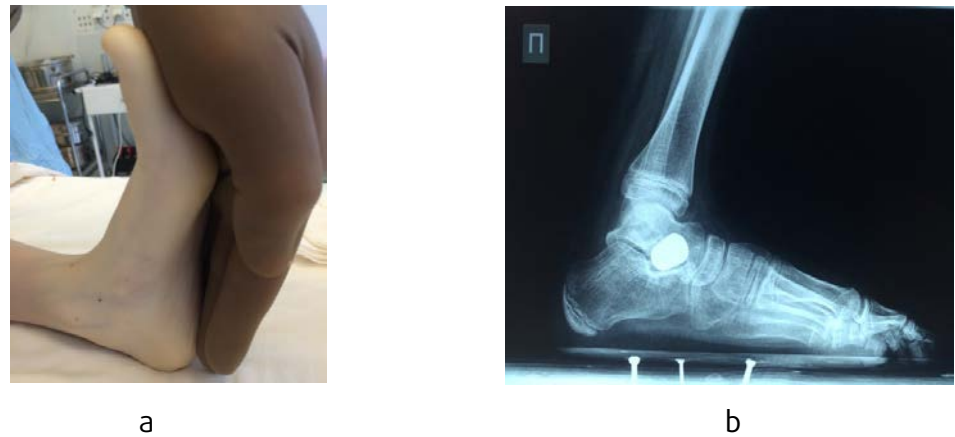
General appearance of foot after operation (a), X-ray examination with implant (b)
